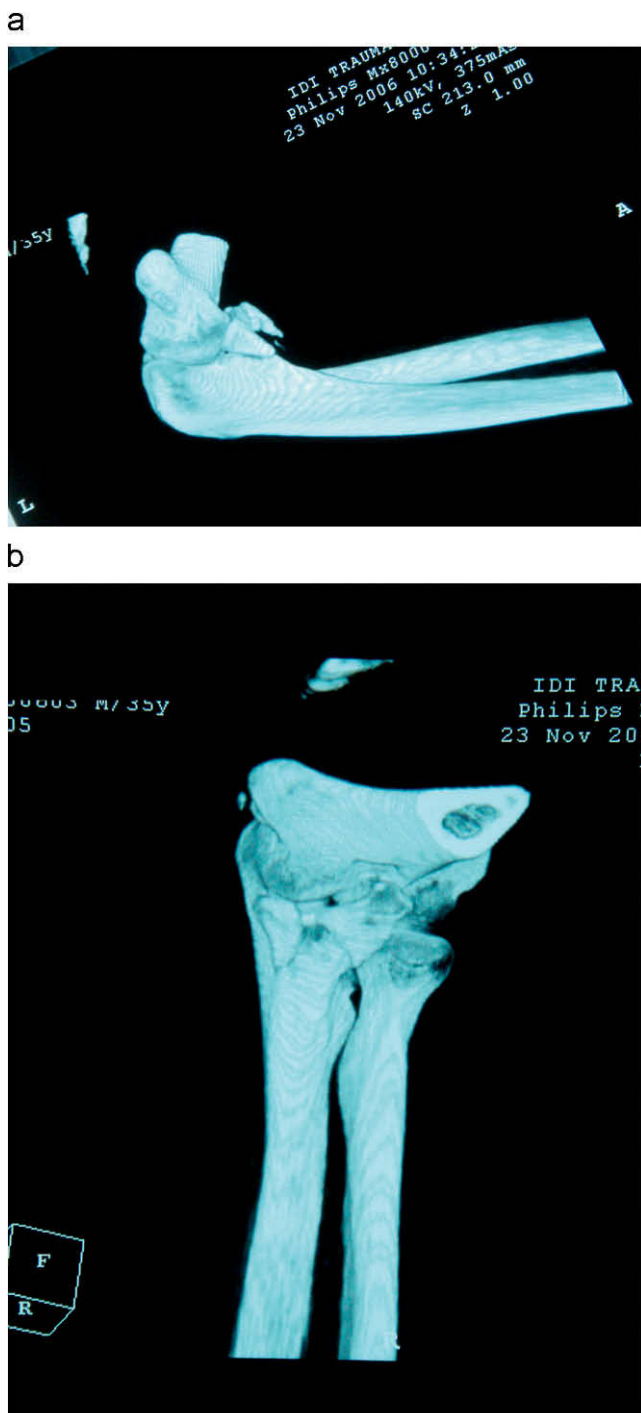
Terrible triad of the elbow. The radial head fracture is accompanied by a small coronoid fracture. This CT exam shows the loss of humeroulnar joint congruity and a posterolateral subluxation of the radial head.
